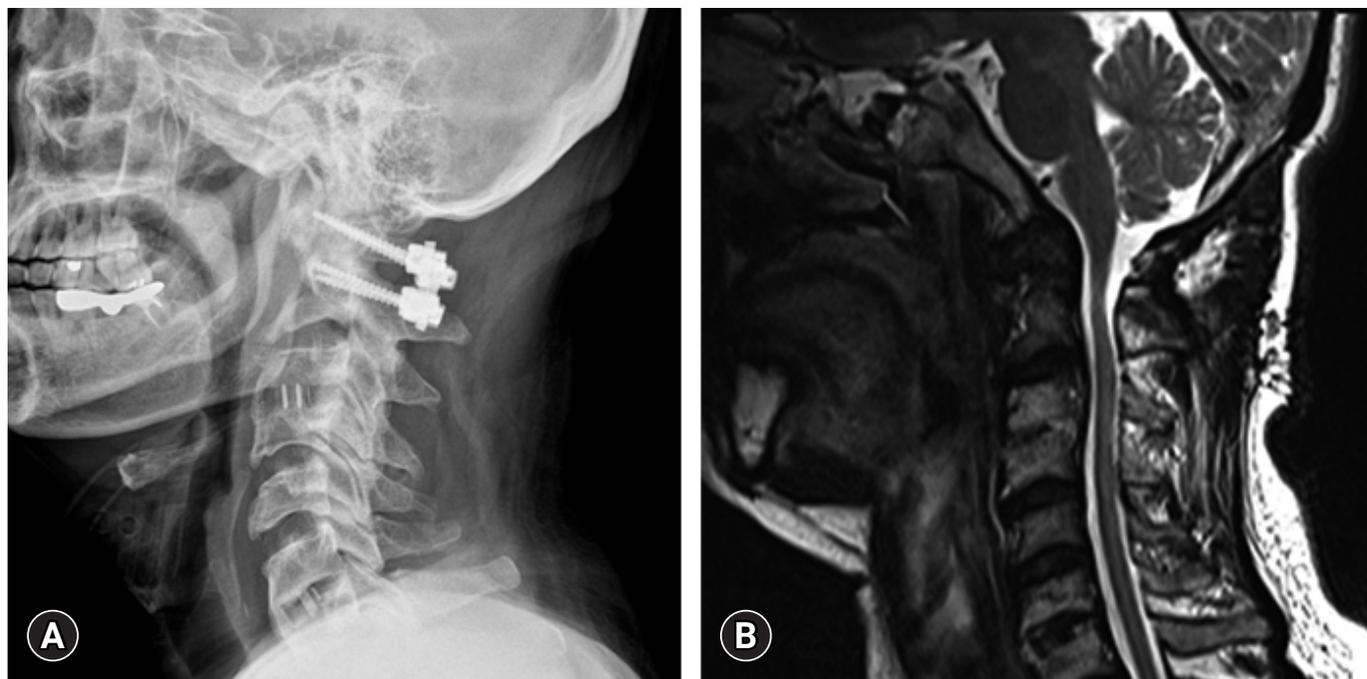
(A) Lateral cervical radiograph showing C1 lateral mass screws and C2 pedicle screws. (B) Follow-up magnetic resonance imaging of the cervical spine revealing a decreased size of the retro-odontoid pseudotumor 3 months postoperatively.
